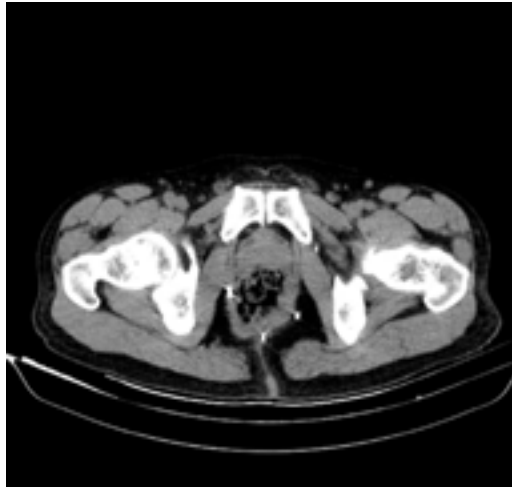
Computed tomography and Foreign bodies
